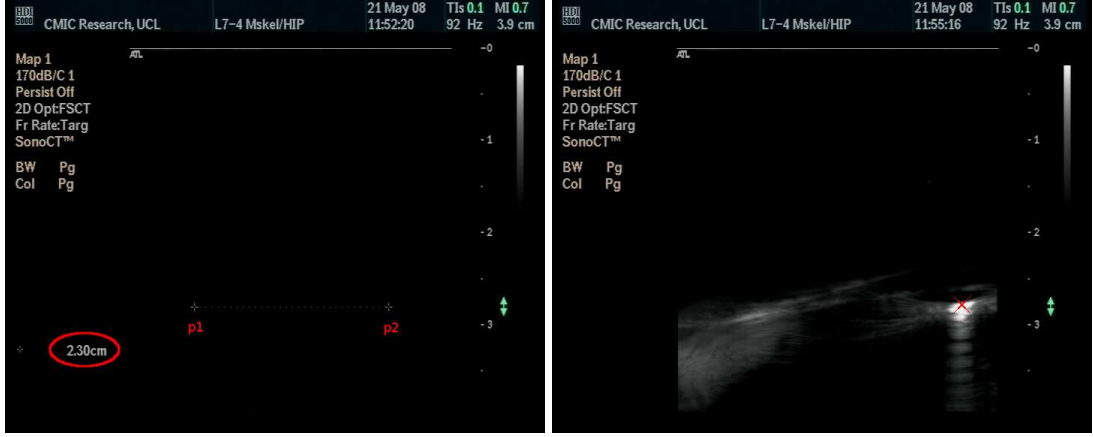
On the left is an example of the measurement used to determine $T_{UI \Rightarrow UP}$. The ultrasound image shows a distance which can be used to determine a pixel to mm value. The origin of the image is defined as the top left corner. On the right is a typical ultrasound image of the pinhead, with a cross indicating its manually segmented position.
